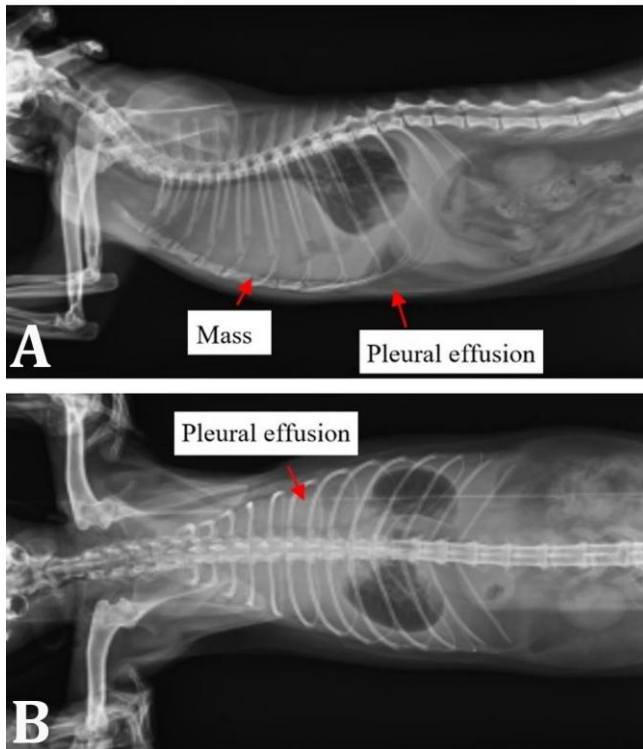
A) Lateral view, and B) supine view of the patient. The thoracic radiographs shows a thymoma and pleural effusion in the cranial mediastinum.
